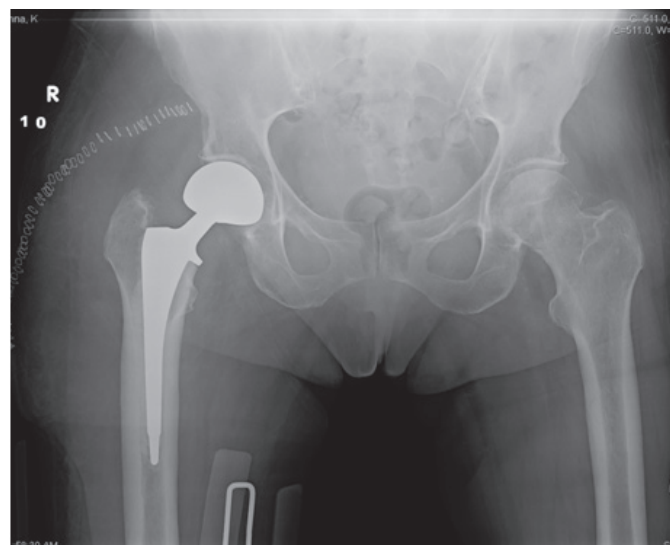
Radiograph of right hip post-reduction (Staples present from original outside surgeon's surgery).
